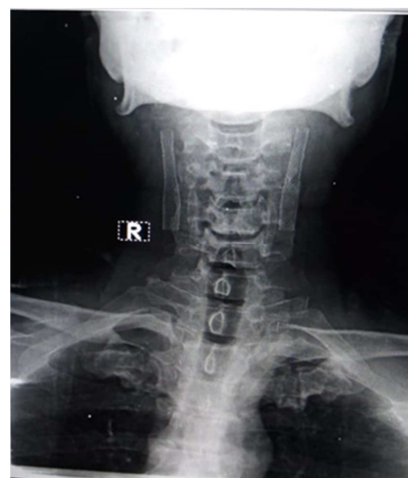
Plain x-ray on the neck after 6 months shows bilateral patent stents with no residual stenosis.
